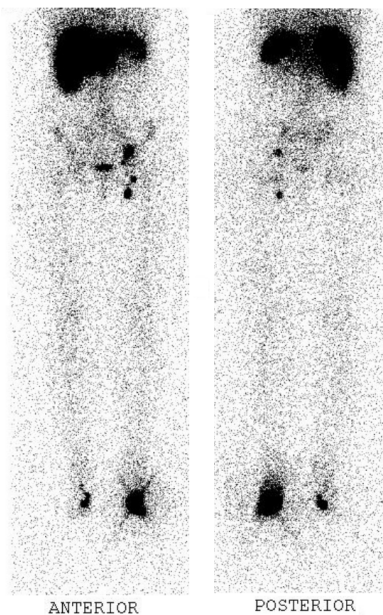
Lymphoscintigraphy of the patient one hour post-injection. Note intense liver uptake as well as low activity of the injection site on the right side. Inguinal lymph nodes on the right side were not visible.
